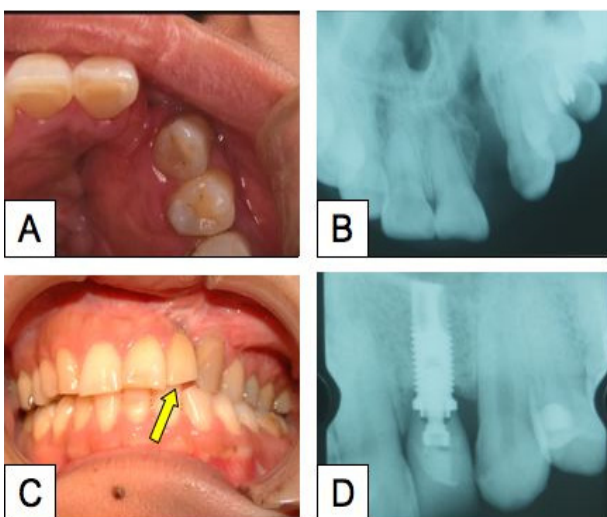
Pictures of patient case 1. A: Note missing left lateral incisor tooth during the first visit. B: Radiograph of alveolar cleft. C: Intraoral view of 2 years after final prosthesis supported by endosseous implant. D: Radiograph of follow-up period.
